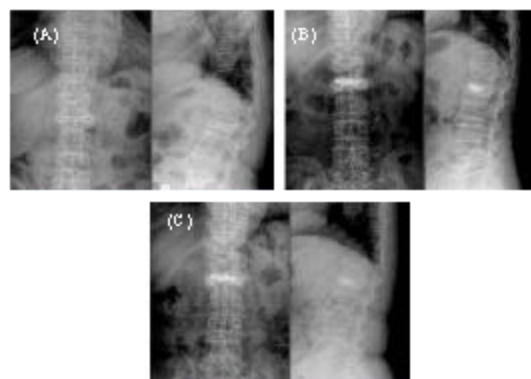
A 69-year-old woman with recent compression fracture on L2. A: A preoperative radiograph shows 43.3% height loss and 26.2° kyphosis of L2, B: A postoperative radiograph shows 20.6% height loss and 12.1° kyphosis of L2, C: 1 year after operation, radiographs shows 24.9% height loss and 14.0° kyphosis of L2
